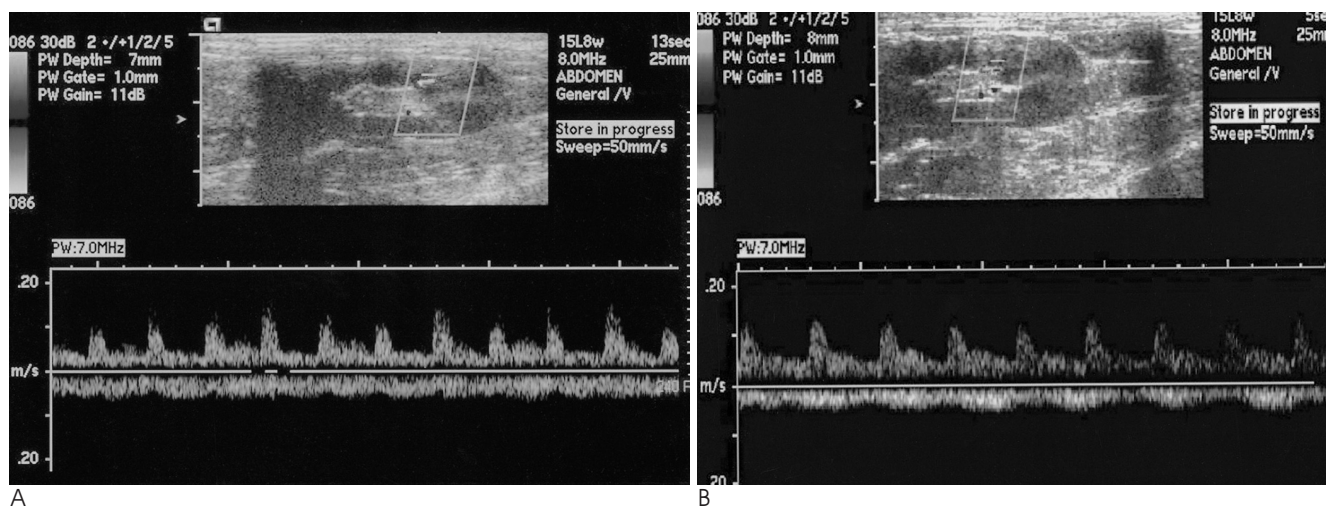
Duplex Doppler sonograms of contralateral nonobstructed kidney before (A) and 30 minutes after (B) ureteral ligation. Doppler sonogram shows preserved normal oscillation in the Doppler waveform of the contralateral nonobstructed kidney after ureteral ligation.
